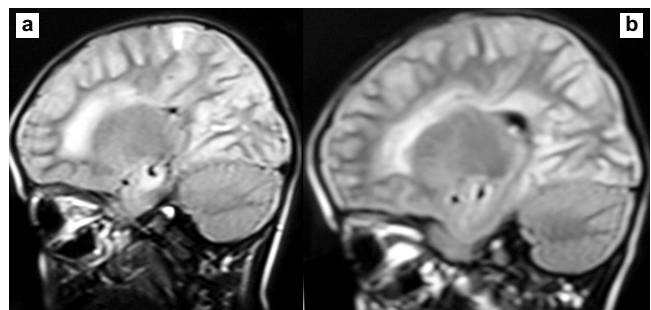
Sagittal FLAIR images (2a and 2b) show symmetric increased signal intensity in the cerebral periventricular and subcortical white matter.
